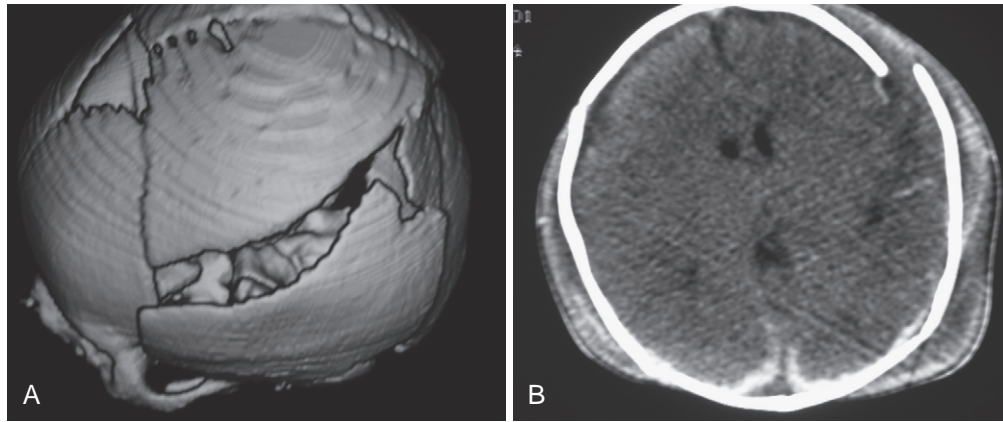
A crushing type injury in an infant. A, This shows a cranial “burst” injury on CT three-dimensional reconstruction of the skull. B, Although there is intracranial hemorrhage and dural laceration, the structure of the brain is preserved and decompressed. The child required dural and cranial reconstruction but recovered with minimal deficits.
